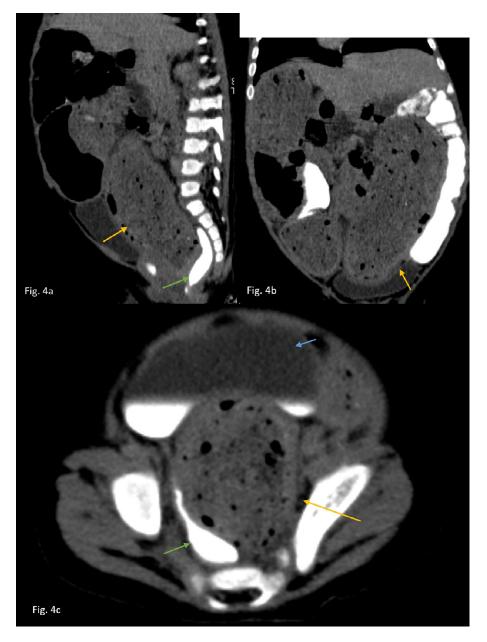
(A-C) – At sagittal (Fig. 4A), coronal (Fig. 4B), and axial view (Fig. 4C) respectively, the CT showed faecal-laden duplication cyst (yellow arrow) causing mass effect onto the contrast filled rectum (green arrow) and contrast-layered urinary bladder (blue arrow). Color version of figure is available online.
